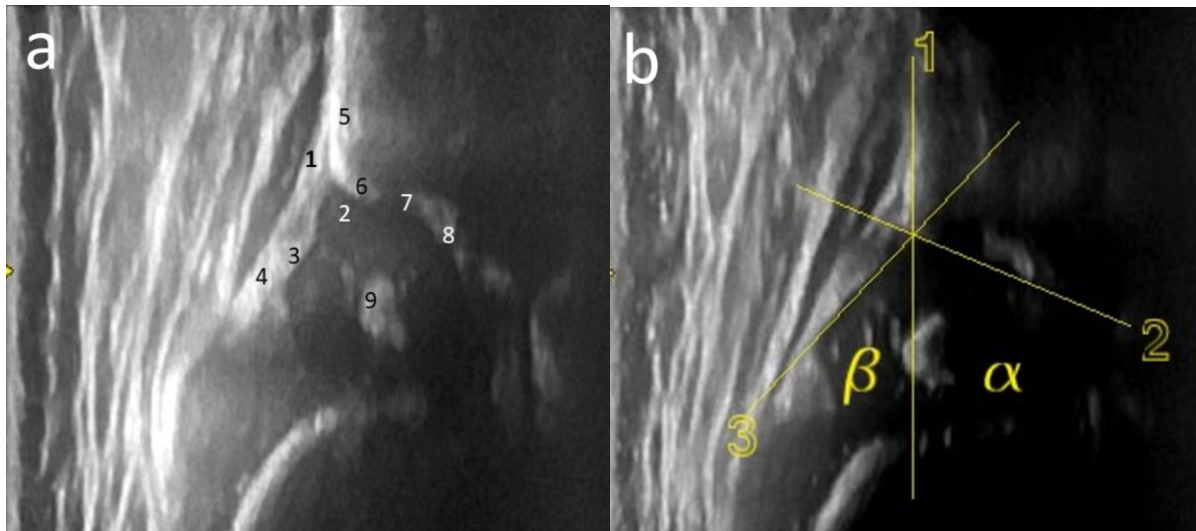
a Explanation of Graf ultrasonogram Image; b Alpha (α) and Beta (β) angles.
